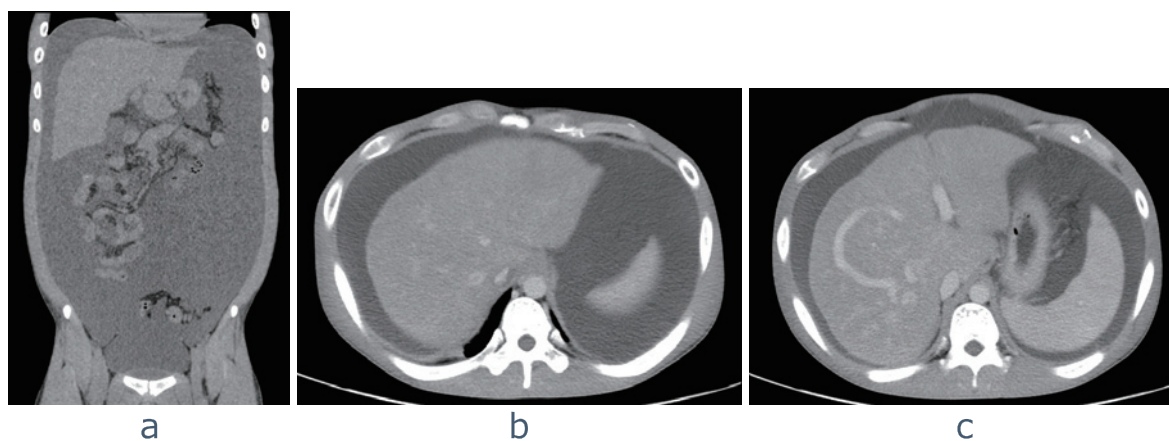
Abdominal CT demonstrated massive ascites (a), ostial occlusion of all three main hepatic veins (b), and development of a comma-shaped intrahepatic veno-venous shunt (c).
